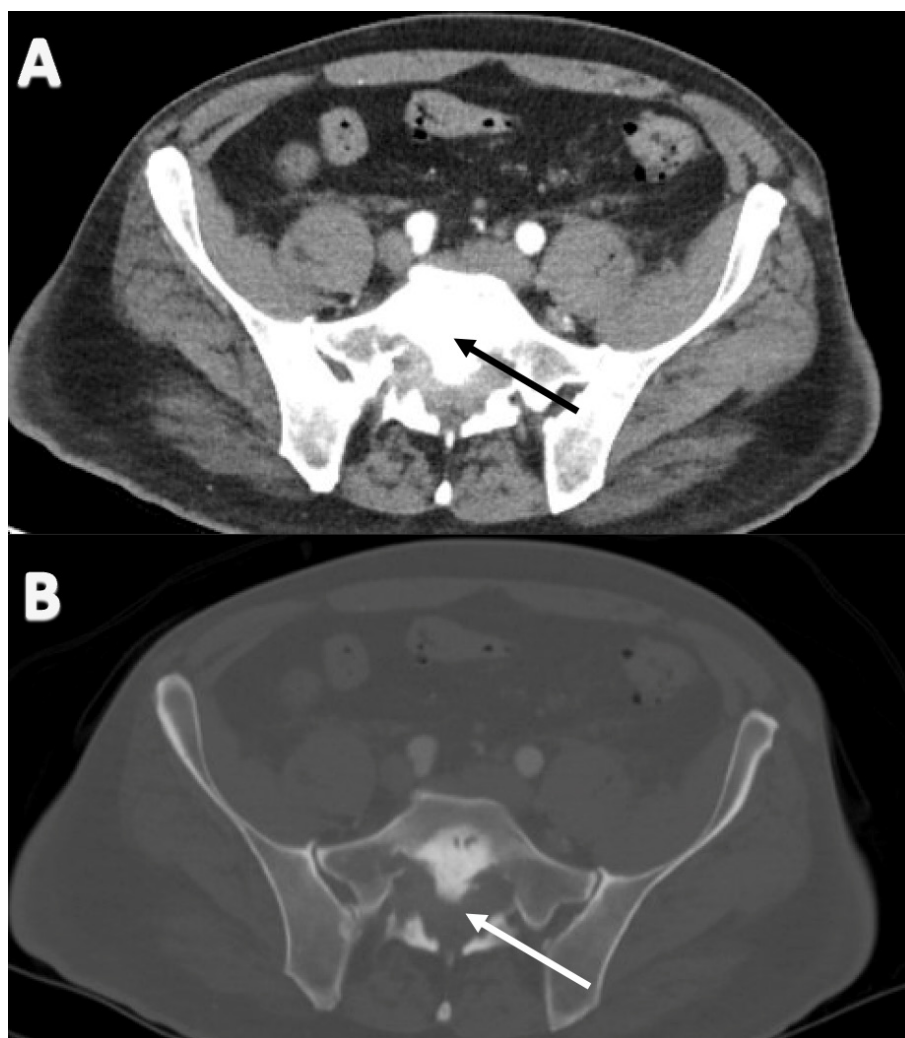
Computed tomography scan of the sacrum depicting mixed lytic and sclerotic lesions of the S1 and S2 sacral body. (A) Sclerotic component of the sacral body as noted by the hyperdense region (*black arrow*). (B) Lytic component of the sacral body as noted by the hypodense region (*white arrow*)
